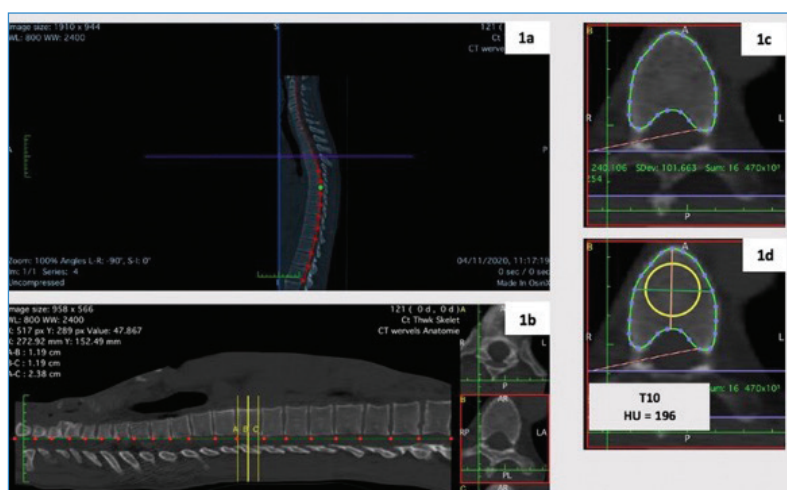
Methodology of low dose Computed Tomography Hounsfield Units (HU) measurement. 1a: Using a three-dimensional curved-multiplanar reconstruction, the curve of the spine adjacent to the spinal canal was delimited. 1b: On the obtained sagittal image, each vertebra (from C3 to L5) was identifiable. At each vertebra, two lines of reference were positioned at the superior (yellow line A) and inferior (yellow line C) limits of the vertebra. Equidistant to A and C, the yellow line B was automatically positioned by the software at the center of the vertebral body. 1c: In the reconstructed cross-sectional slice, the vertebral body was manually delimited. 1d: A region of interest was manually selected, having a diameter equal to 75, of the average of anteroposterior and transverse diameters. The density of the vertebra was displayed by the software as the average image intensity within the sample region, reported in HU.
